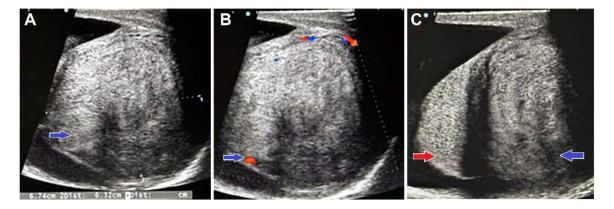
Ultrasound of the scrotum demonstrating a heterogeneously hyperechoic solid lesion in the paratesticular region of the right hemiscrotum with minimal vascularity on Doppler imaging (blue arrows). The right testis appears normal (red arrow).
